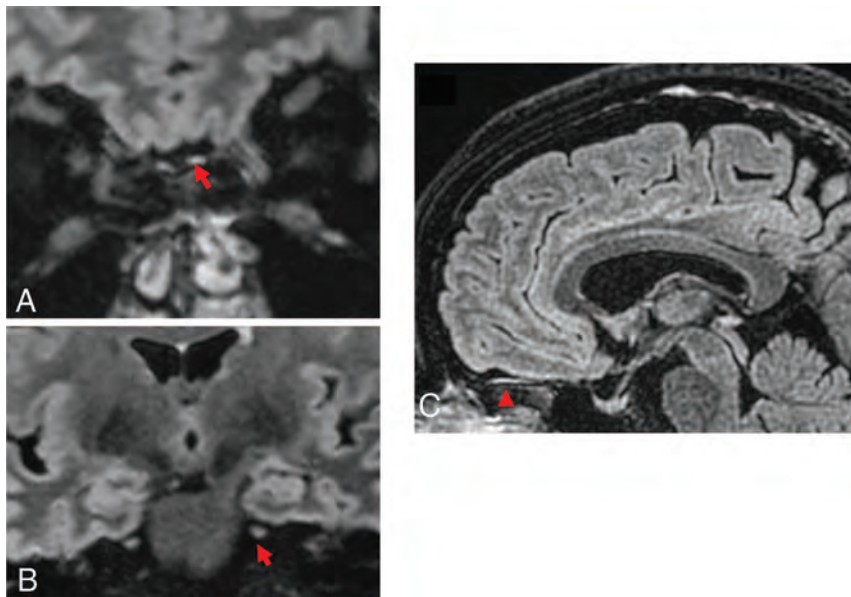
A 52-year-old woman positive for COVID-19 and with a history of major depressive disorder, was found to be catatonic. *A*, Coronal and (*B*) sagittal postcontrast 3D T2 FLAIR demonstrates increased intraneural signal within the OBs (red arrows) relative to (*C*) coronal postcontrast 3D T2 FLAIR images of the trigeminal nerve (red arrow).
